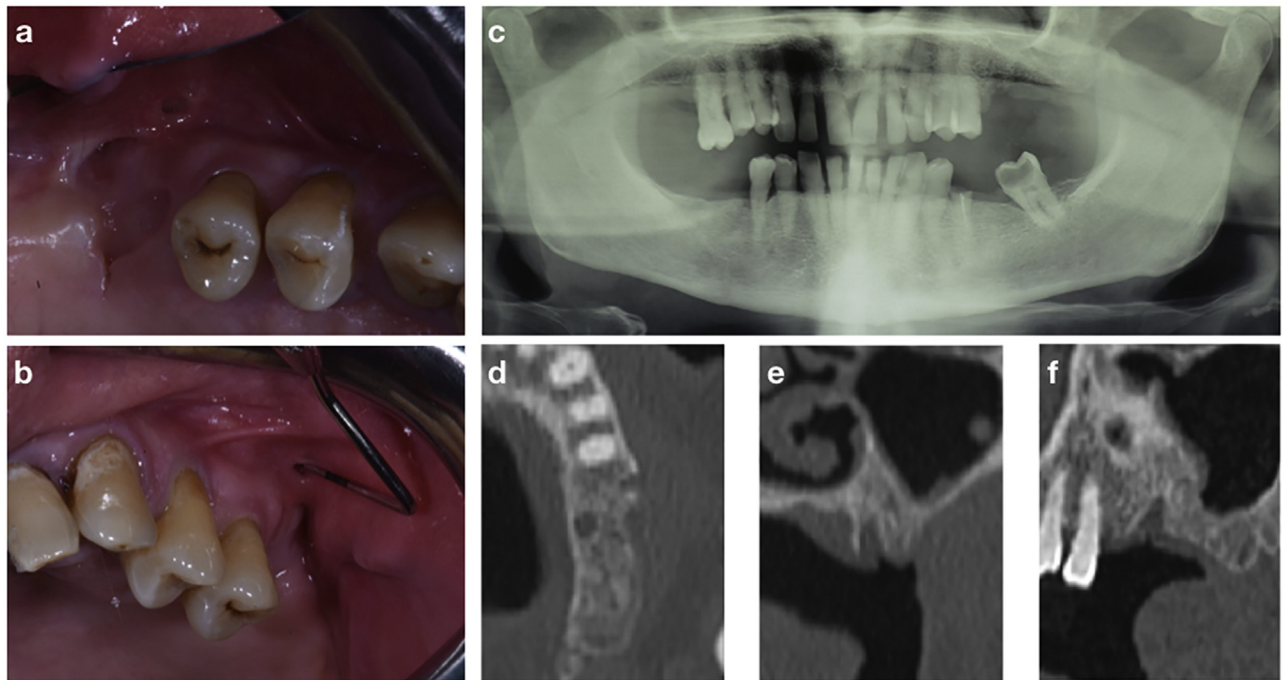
Left-sided maxillary MRONJ: (a) (b) clinical views; (c) panoramic X-ray; (d) (e) (f) computed tomography scan sections.
